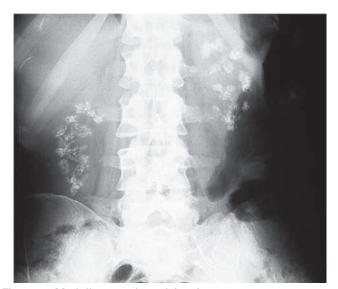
Medullary nephrocalcinosis. Plain radiograph showing bilateral metastatic medullary nephrocalcinosis in a patient with distal renal tubular acidosis.
